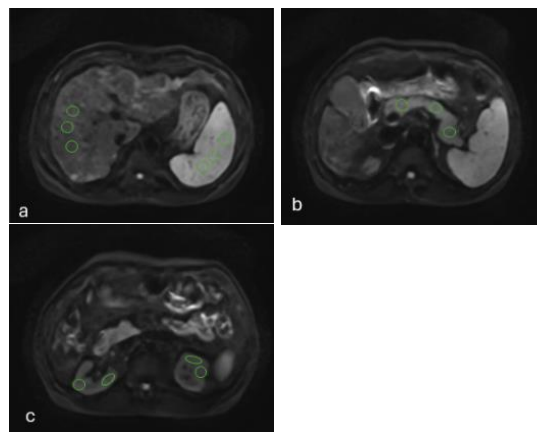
Three circular regions of interest (ROIs, circles) of approximately 100 pixels were placed within the right hepatic lobe, spleen, and pancreatic body, and two circular ROIs within the left and right kidneys, on the DWI image.
